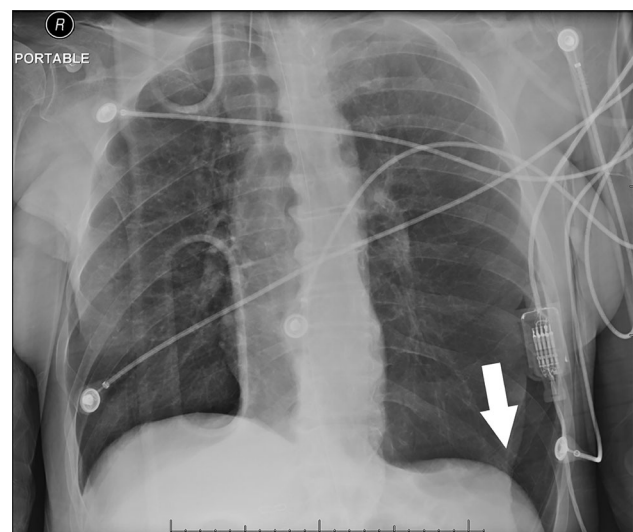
A single supine AP radiograph with the patient on a trauma backboard shows depression of the left diaphragm with a “deep sulcus sign” (arrow) indicating a basilar pneumothorax in a supine patient
